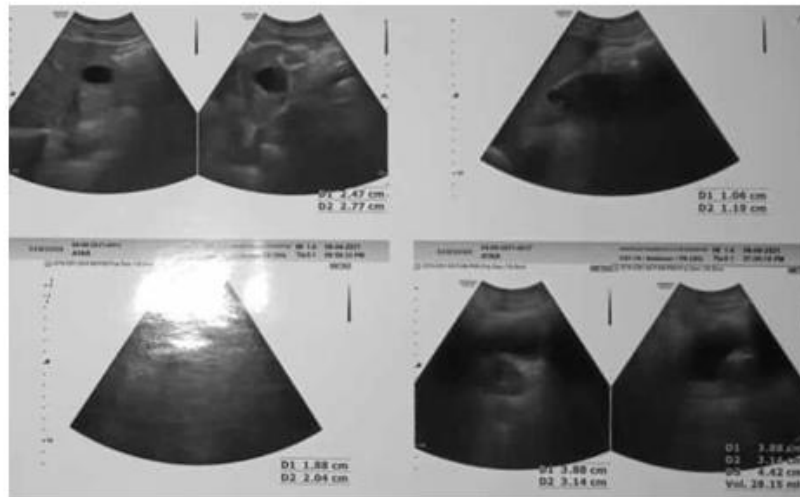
Post Operative Sonography done after 5 months
